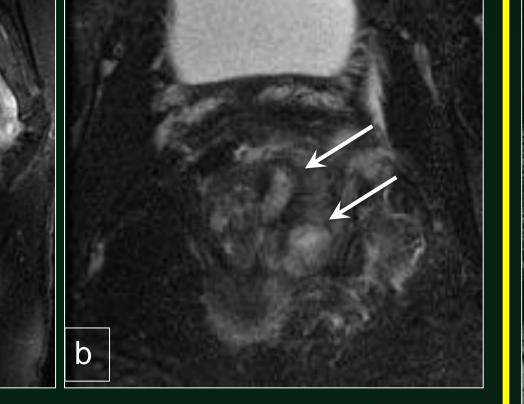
Crohn disease. Sagittal proton density FS image (a) depicts rectal wall thickening (arrowhead) and mural edema. Axial T2-weighted FS image (b) reveals perianal abscesses (arrows) and extensive soft tissue edema.
